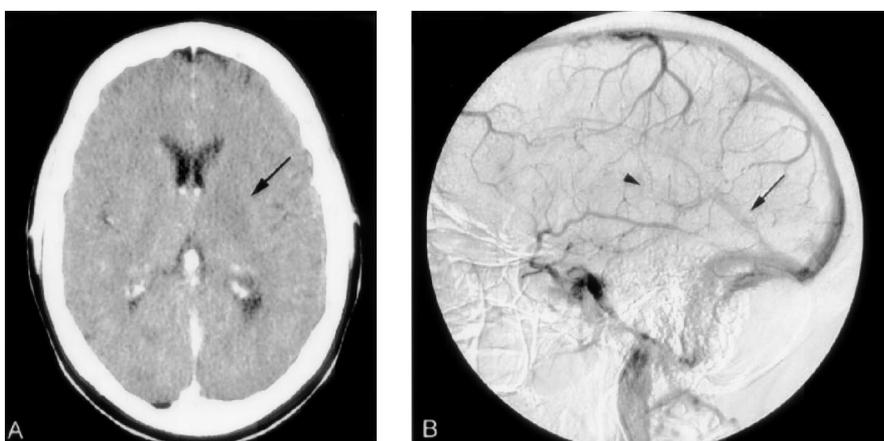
Case 4. (A) Brain CT showing a hypodense lesion in the left thalamic region with no contrast enhancement. (B) Sagittal digital subtracted catheter angiography showing partial filling of the internal cerebral vein, and straight sinus.
